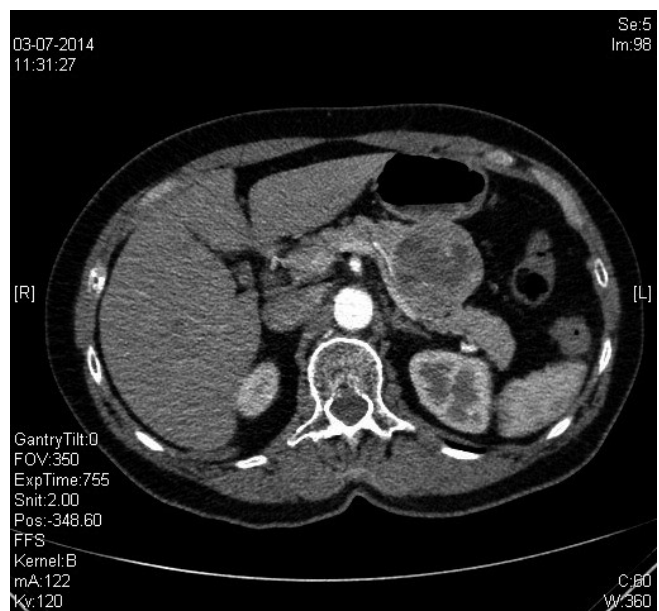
Contrast-enhanced CT scan of the abdomen showing a well-circumscribed tumor with cystic areas in the pancreatic tail. There is no involvement of the lymph nodes.
